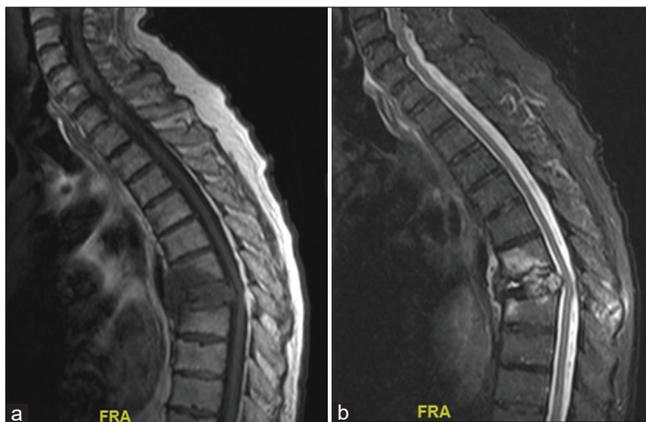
(a) Sagittal magnetic resonance imaging (MRI) thoracic spine with contrast showing metastatic lesion at T7 without enhancement. (b) Sagittal MRI thoracic spine with short tau inversion recovery sequence showing hyperintensity at the affected level, suggesting edema and acute fracture. FRA: Front.
